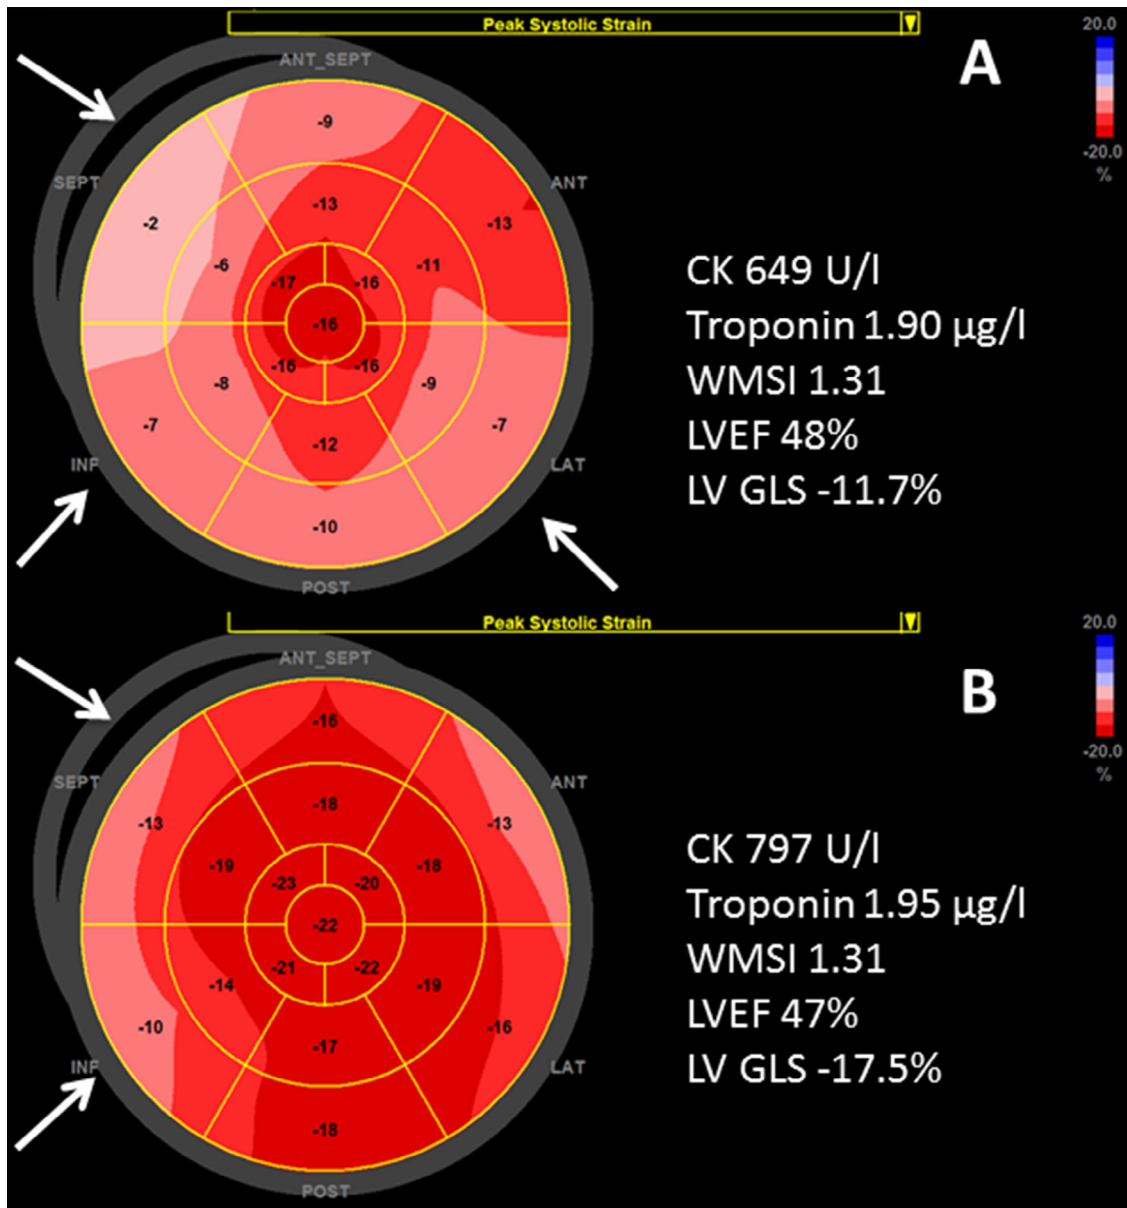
Bull's-eye plot of left ventricular (LV) global longitudinal strain (GLS) assessed by speckle tracking echocardiography. (A) STEMI patient with COPD (culprit vessel RCA), with LVEF 48% (comparable with patient B without COPD). LV GLS was more impaired (less negative) than in patient B without COPD, -11.7% vs -17.5% , respectively. (B) STEMI patient without COPD (culprit vessel RCA) with LVEF 47%. Biomarkers for infarct size (CK and troponin) were similar in both patients. Arrows indicate the infarct location. ANT = anterior; ANT_SEPT = anteroseptal; CK = creatine phosphokinase; INF = inferior; LAT = lateral; LVEF = left ventricular ejection fraction; POST = posterior; RCA = ramus descendens anterior; SEPT = septal; WMSI = wall motion score index.
